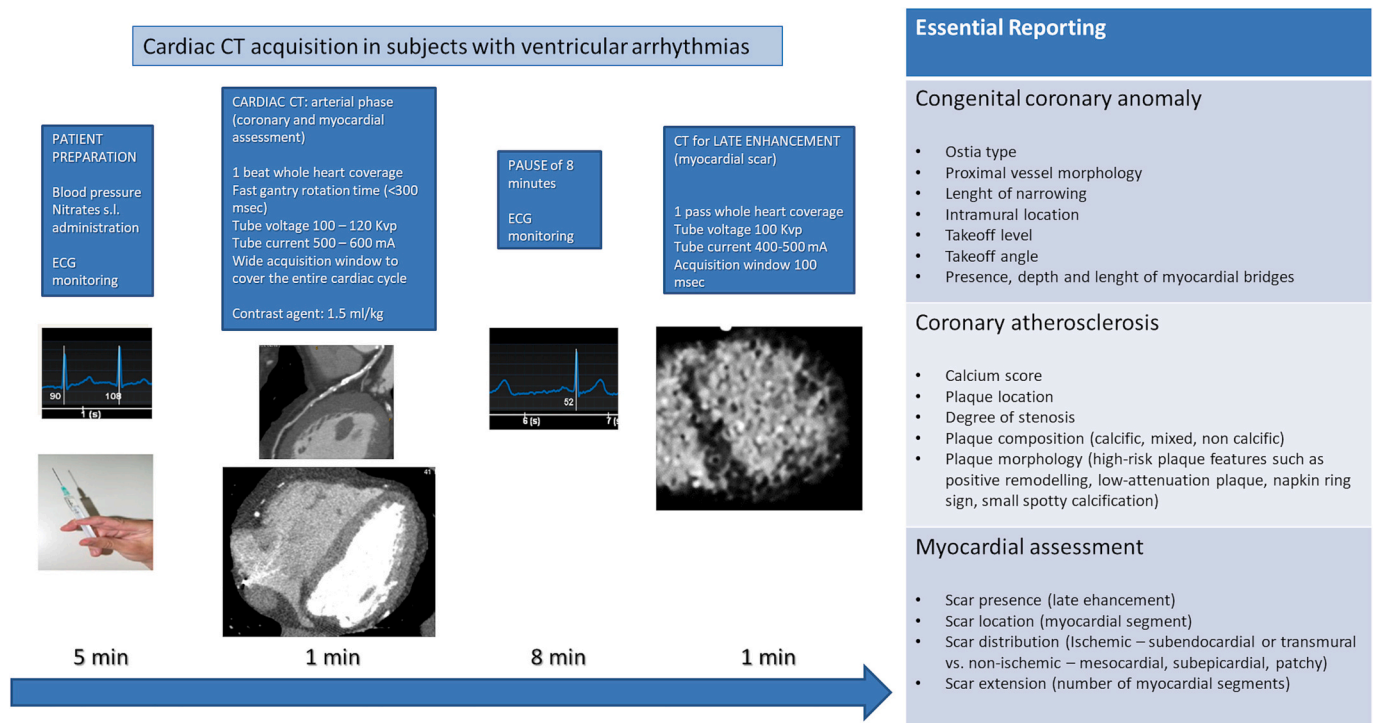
Protocol of cardiac computed tomography acquisition and reporting in athletes referred for ventricular arrhythmias. Note that modern technologies may allow the evaluation of coronary arteries and myocardial assessment for late enhancement, although a second scan is required.
